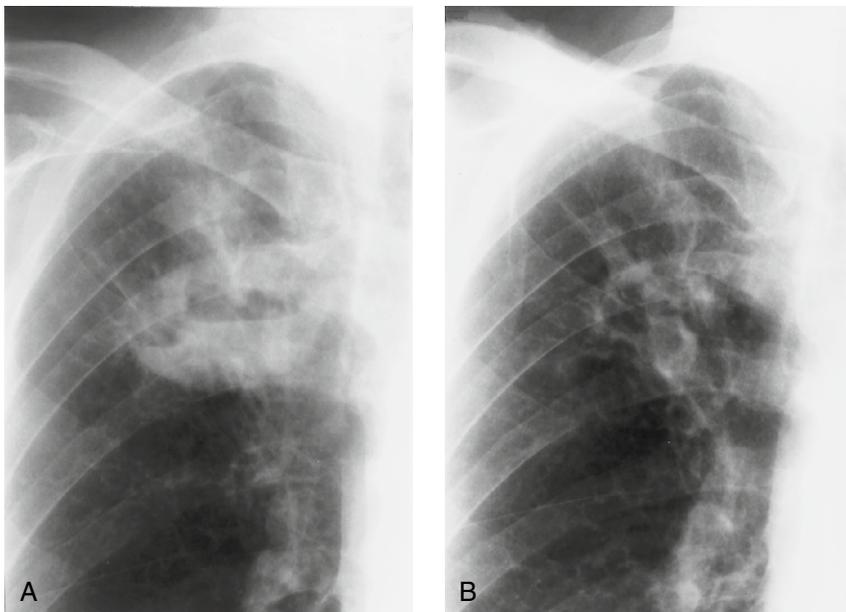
Chronic progressive coccidioidomycosis in a 50-year-old man with chronic coccidioidomycosis. (A) PA chest radiograph coned to the right upper lobe shows a complex cavitary focus of airspace opacity with multiple air-fluid levels. (B) Ten months later, a PA chest radiograph of the same area shows significant reduction in size of the cavitary disease and interval development of fibronodular opacities.
